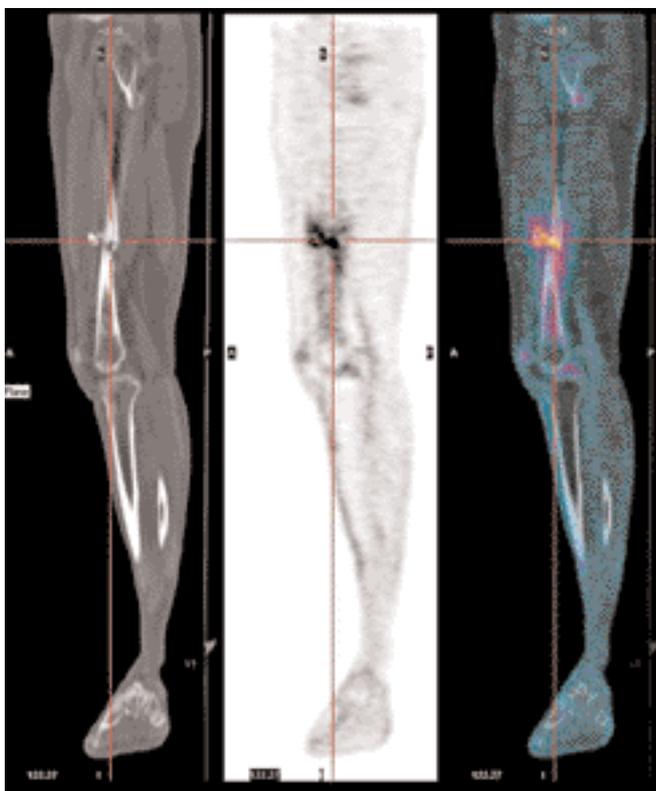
FDG PET/CT of a 51-year-old man in whom post-traumatic osteomyelitis of left femur was suspected. Sagittal images: PET alone (center) shows increased FDG uptake in the mid left thigh, that PET/CT (right) precisely localizes in the femur and surrounding soft tissues; the corresponding CT scan is on the left. FDG: F-18 fluorodeoxyglucose; PET: positron emission tomography; CT: computed tomography.
